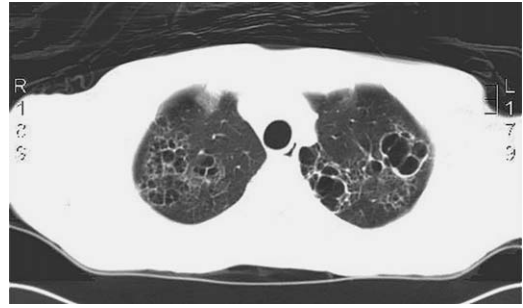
CT scan of pneumatoceles caused by *P carinii* pneumonia infection.
